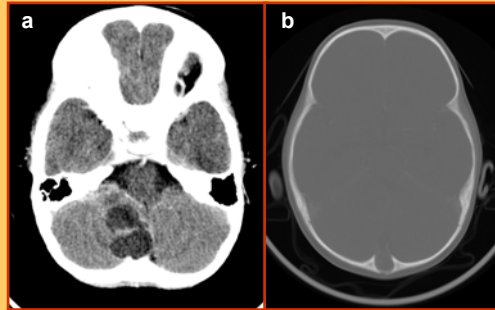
Axial CT a) Non-contrast and 1b) "bone window" image
